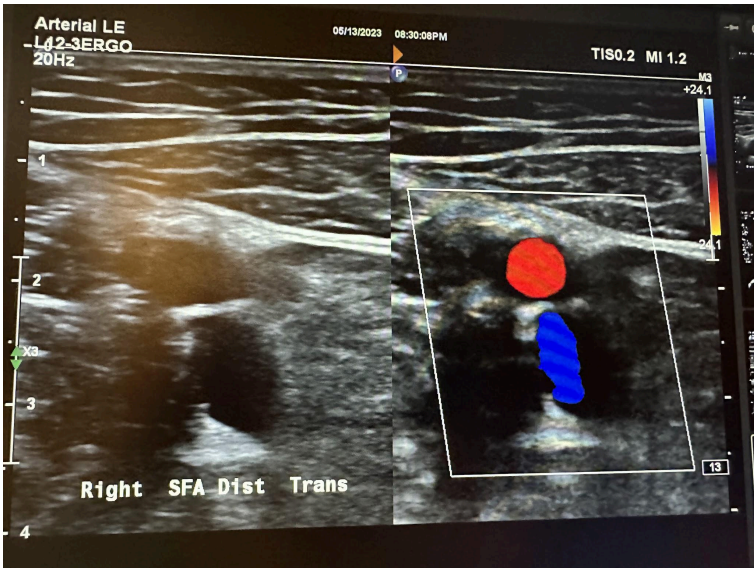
Side-by-side transverse images of the right distal superficial femoral artery without color Doppler and with color Doppler.
